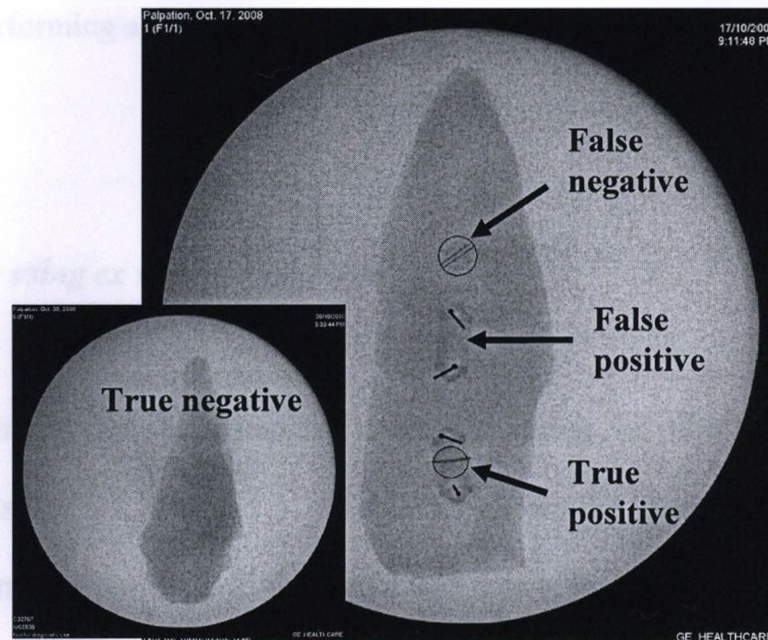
Fluoroscopic radiographic images of tissue samples. Visual representations of the four success rate measures are indicated.
